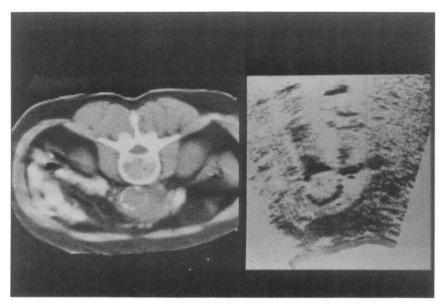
Ultrasound and CT scan of patient with retroperitoneal fibrosis. Thick plaque of fibrotic material is observed stretching over the aorta.
